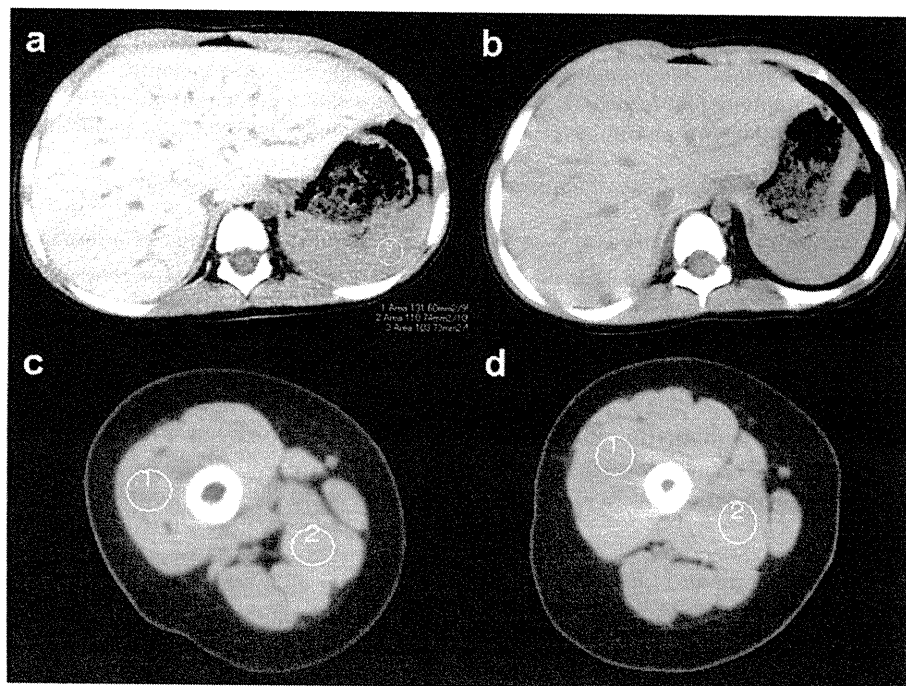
Abdominal and skeletal muscle CT scans at first admission (a and c) and 3 months after starting ERT (b and d). Note, the high density of the liver with high CT number of 106 HU at first admission (a) had improved markedly after 3 months with 73 HU (b). Whole muscle showed an increased CT number over 94 HU at first admission (c). There was no remarkable visible change, but CT number improved to 83 HU after ERT (d).
